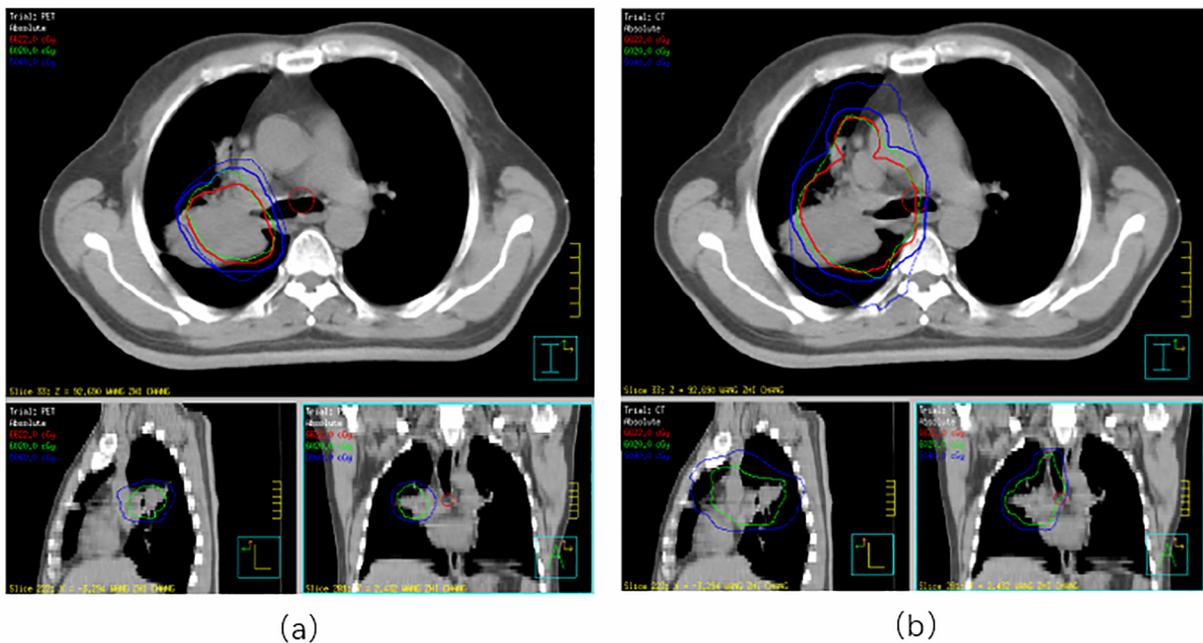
The comparison of dose distribution in Plan_{PET} (a) and Plan_{CT} (b) for a patient.
